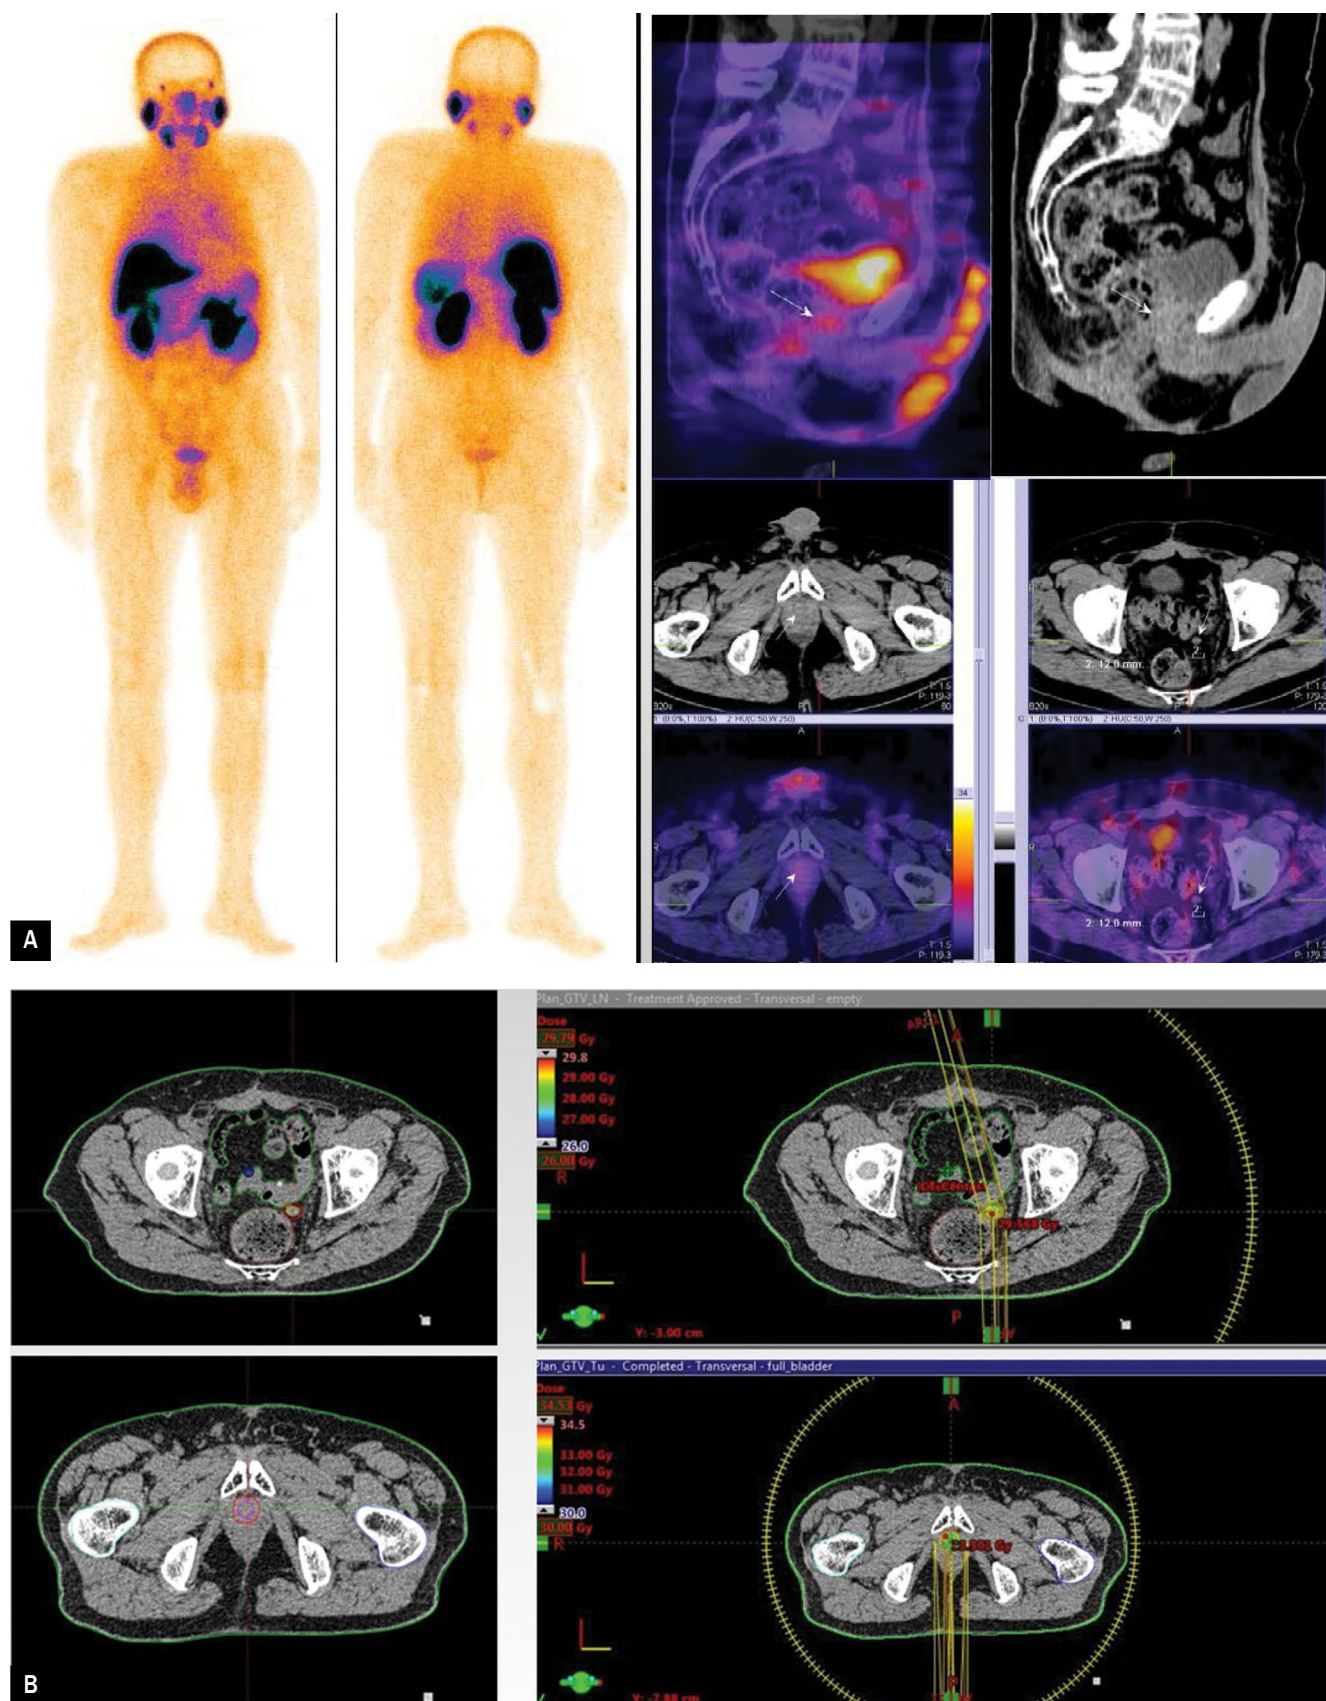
M/75yr with prostate cancer, pT2cpN0M0, G2, GI = 7 (4 + 3). Radical prostatectomy, radiotherapy (2015) and androgen deprivation therapy. PSA = 0.57 ng/mL (03/2019). Whole-body scan and target [^{99m}Tc]Tc-PSMA-T4 SPECT-CT imaging showed local recurrence in the prostate bed and enlarged single perirectal lymph node on the left with intensive tracer uptake; B. Gross tumour volume (GTV) and Clinical Tumour Volume (CTV) delineation based on the [^{99m}Tc]Tc-PSMA-T4 imaging results in radiotherapy planning. Radiation dose distribution in the region of the local recurrence and the single enlarge perirectal lymph node on the left in the same patient
